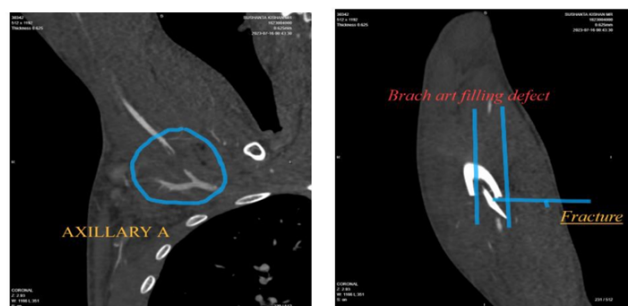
Pre op CT-angio showing axillary artery Filling defect
